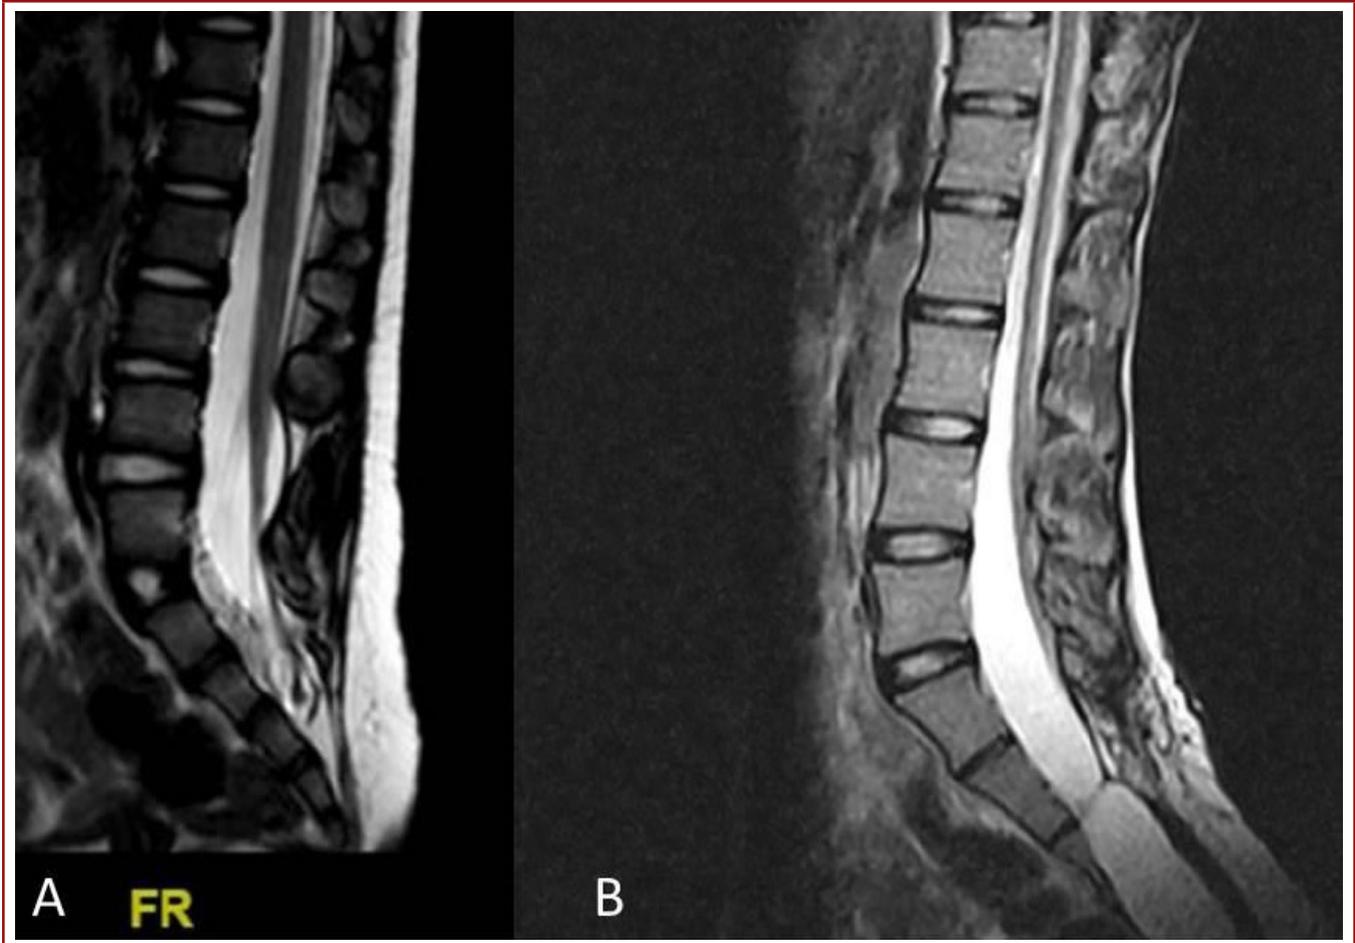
Preoperative sagittal MRI of the *Case-1* (A) and *Case-2* (B).
